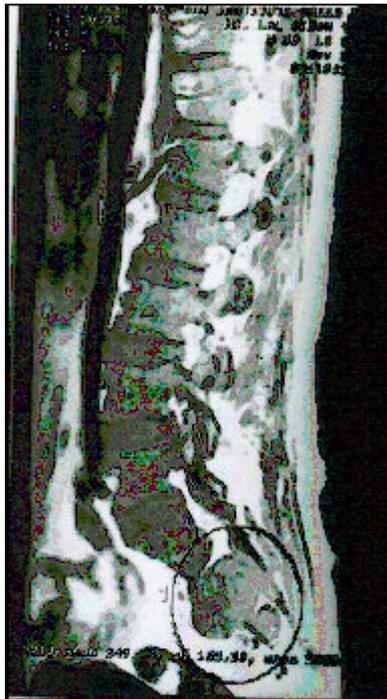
MRI of spine in an elderly male shows sacral deposit from multiple myeloma (Courtesy: Dr. Mohanty and Dr. Bansal)
